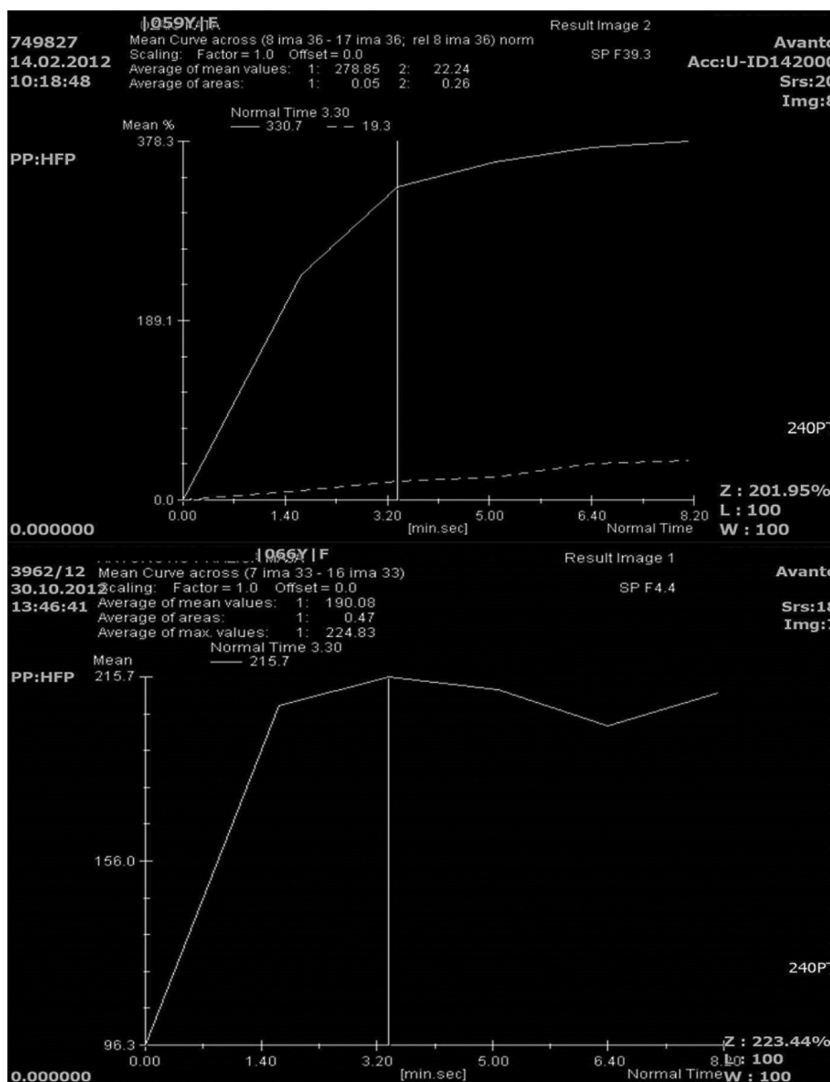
Features of MRI dynamic curves that are more often associated with triple negative breast cancers: in first 2 minutes after contrast admission fast wash in and after first 2 minutes persistent and plateau type of curve.
